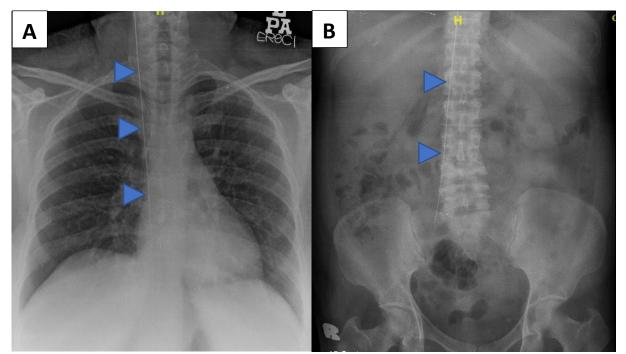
Figure 1: The chest (A) and abdominal (B) radiograph show the neglected J-tip guidewire (arrowhead) likely in the right internal jugular vein extending to the inferior vena cava (IVC).
